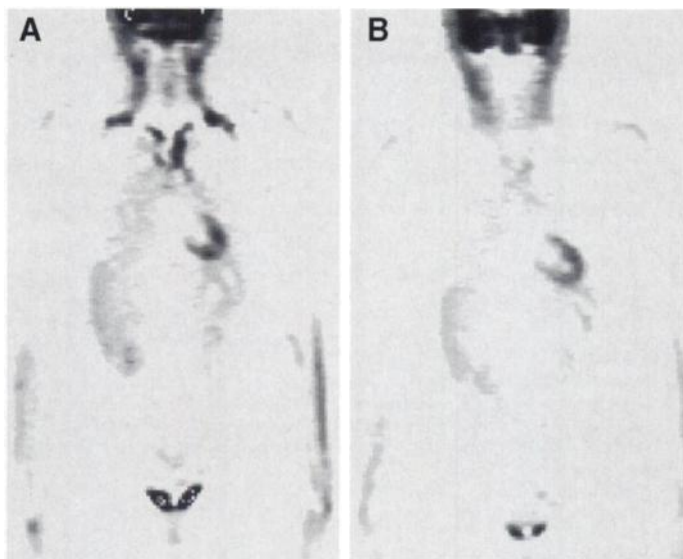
(A) Intense “physiological” uptake of FDG in the strap muscles of the neck and sternocleidomastoid masks potential sites for disease spread in this patient with synovial sarcoma. (B) The same patient underwent rescanning 4 wk later. After administration of 5 mg oral diazepam 30 min before injection of FDG, neck uptake is no longer visible.
